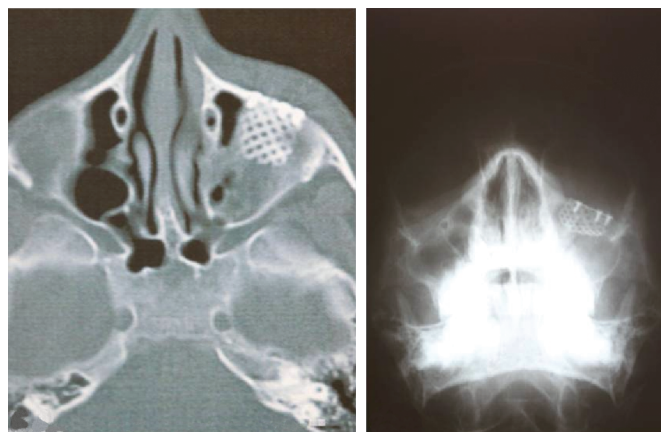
a) Sagittal CT showing the proper placement of titanium mesh. b) Incidence of Waters for postoperative control.
